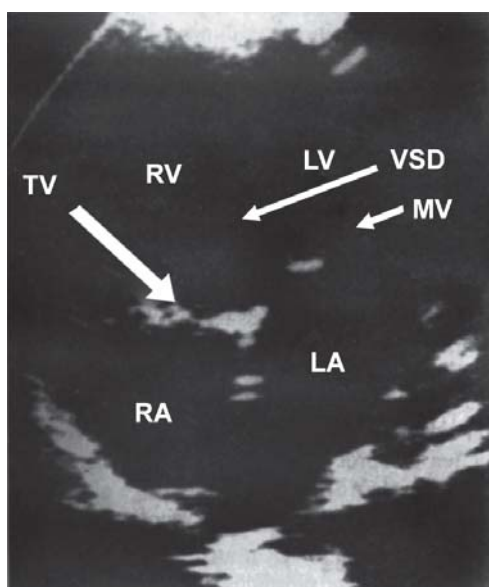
Echocardiography (two-dimensional apical four chamber view) demonstrating VSD and tricuspid atresia (TA) along with transposition of great arteries (TGA)
